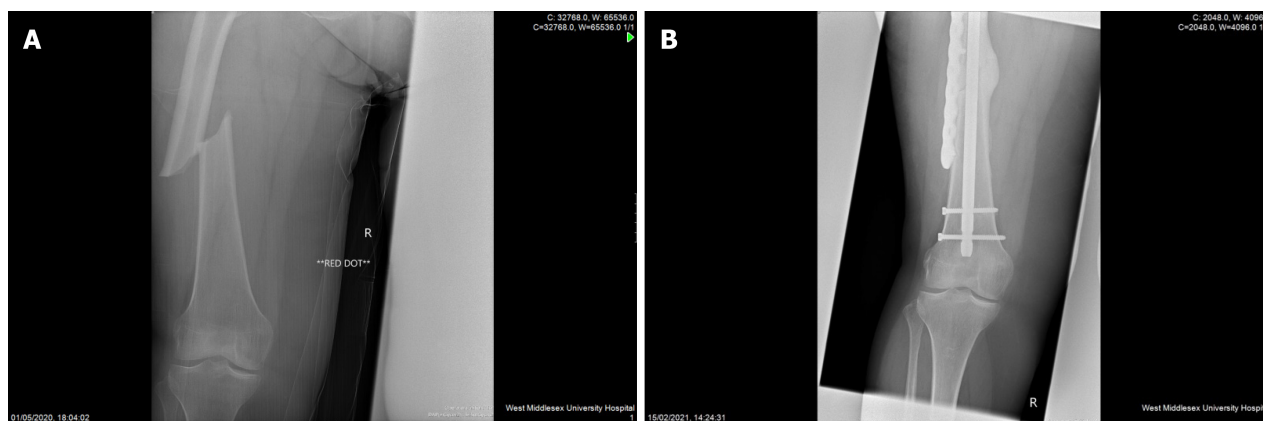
Plain radiographs before and after atypical bisphosphonate associated femoral fracture fixation. A: Before atypical bisphosphonate associated femoral fracture fixation; B: After atypical bisphosphonate associated femoral fracture fixation.
